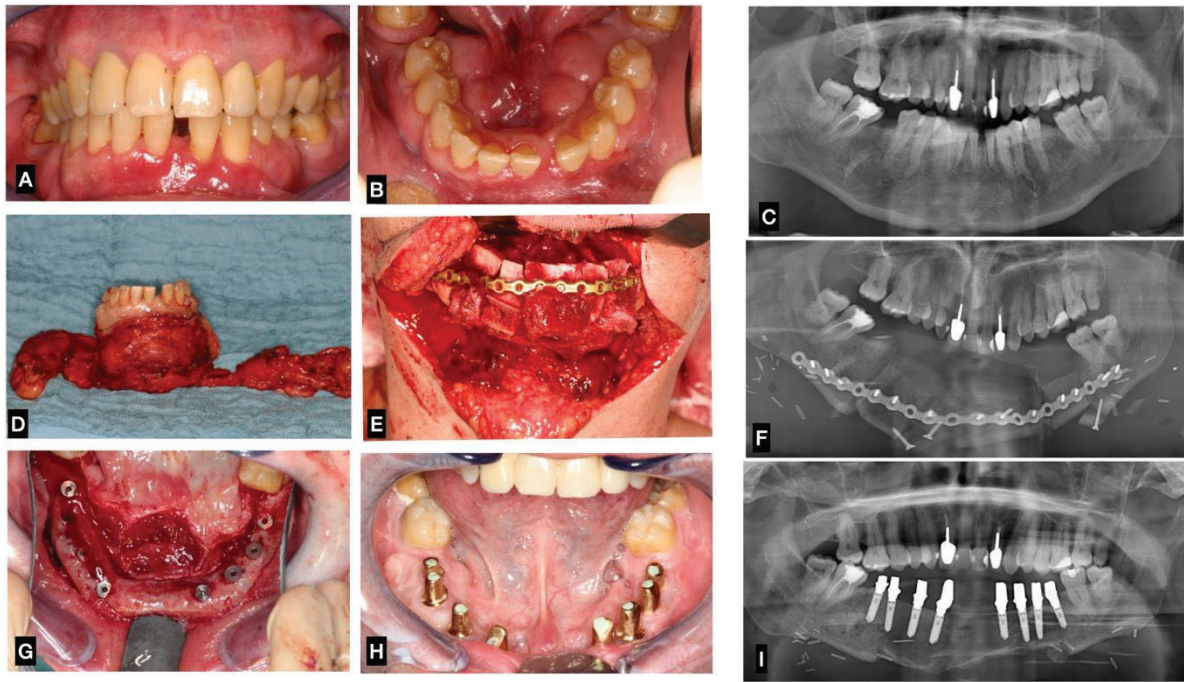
Jaw reconstruction by means of a DCIA flap: A–C) initial intra-oral photos and radiograph of patient diagnosed with osteosarcoma in the anterior of the mandible; D) tumor resection; E) jaw reconstruction; F) postoperative panoramic x-ray; G) implant insertion; H–I) intra-oral photo and radiograph after prosthetic rehabilitation. Clinical case of the Department of Oral and Maxillofacial Surgery, University Hospital Giessen.
